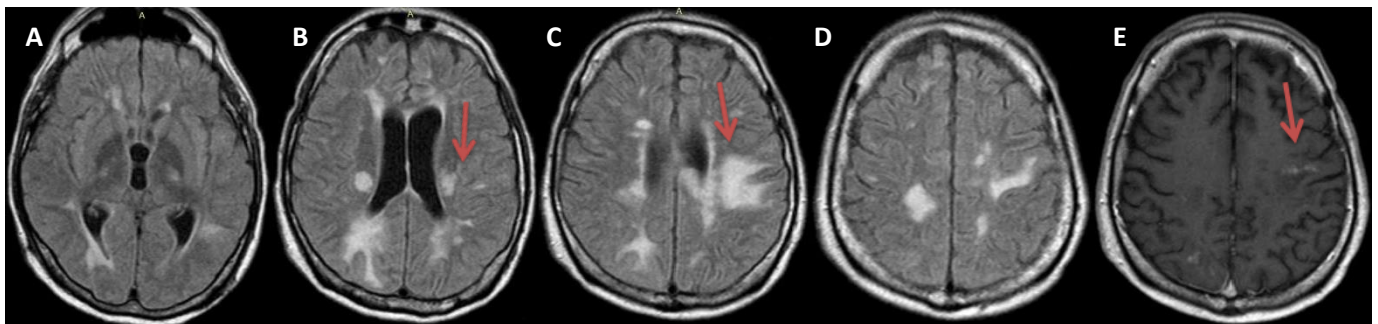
Brain MRI in June 2021. A-D: The demyelinating lesions on the left periventricular white matter and on the left parietal lobe (red arrows) are smaller in size and less diffuse. E: Patsy gadolinium enhancement in the demyelinating lesions in the white matter bilaterally and in the left frontal juxtacortical white matter (red arrow).
